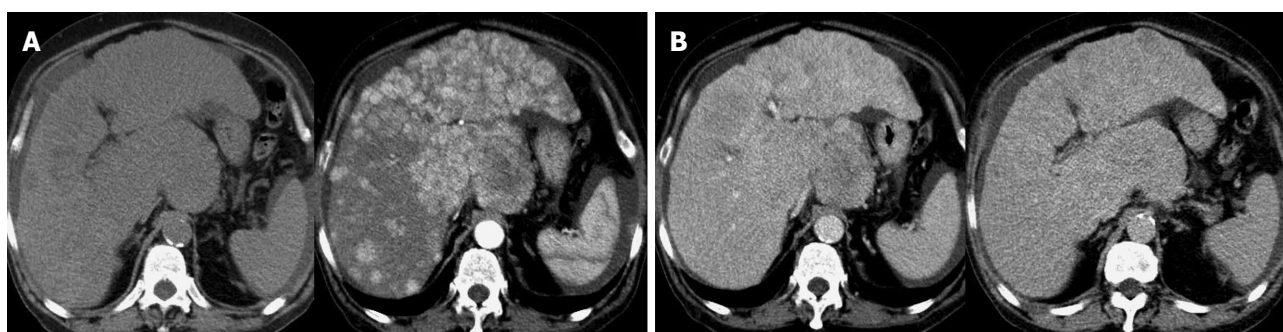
Multi-nodular hepatocellular carcinoma. A: Basal and arterial computed tomography (CT) phase; B: Venous and late CT phase.
